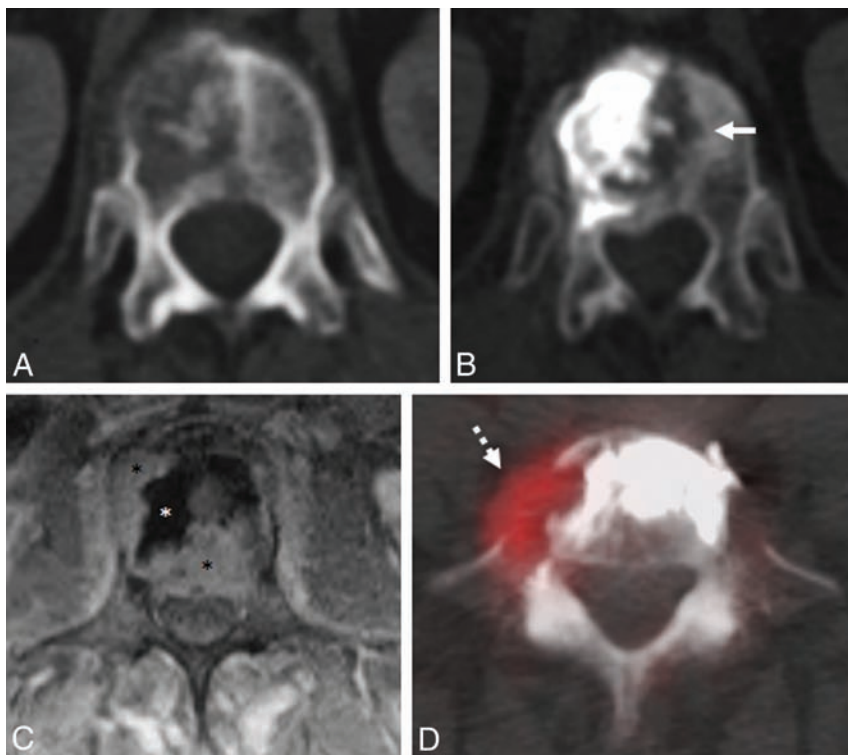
Examples of ablation failure. A, Axial CT image shows a T12 lytic squamous cell carcinoma metastasis. B, CT scan obtained 4 months after radiofrequency ablation and vertebral augmentation shows new osteolysis medial to the cement and extending across the midline (*white arrow*), consistent with progression of residual tumor. C, Axial postcontrast, T1-weighted, fat-suppressed MR imaging performed 6 months after radiofrequency ablation and vertebral augmentation of an L3 non-small cell carcinoma metastasis shows signal void corresponding to cement in the ablation cavity (*white asterisk*), with residual enhancing tumor in the right lateral and posterior vertebral body that extends into the epidural space (*black asterisks*). D, Axial [^{18}F] fluorodeoxyglucose PET/CT scan obtained 1 month after radiofrequency ablation and vertebral augmentation of an L5 liposarcoma metastasis shows residual hypermetabolic tumor along the right anterolateral aspect of the vertebral body (*white dashed arrow*).
